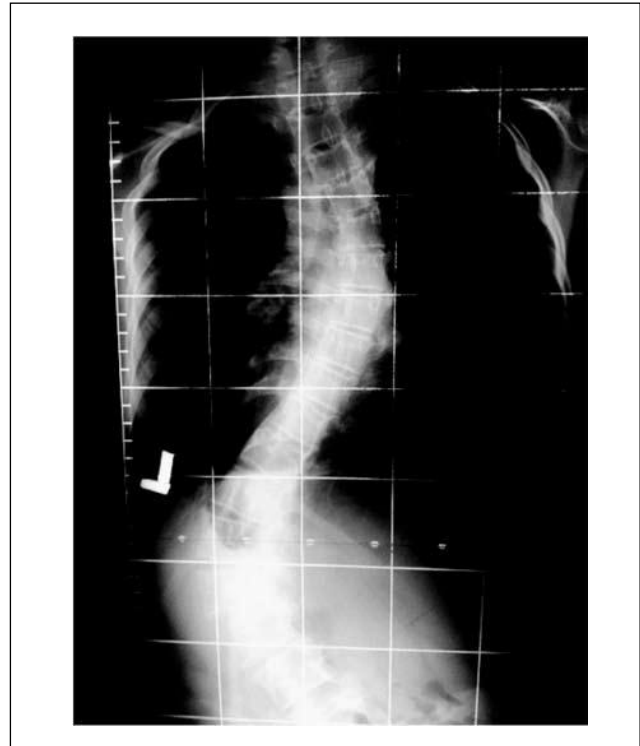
AP-X-Ray of a cystic fibrosis patient (16 year-old girl) with thoraco-lumbar scoliosis. Cobb angle of the thoracic curve is 40 degrees, lumbar 60 degrees. Both – thoracic and lumbar curves are seen in the picture.
